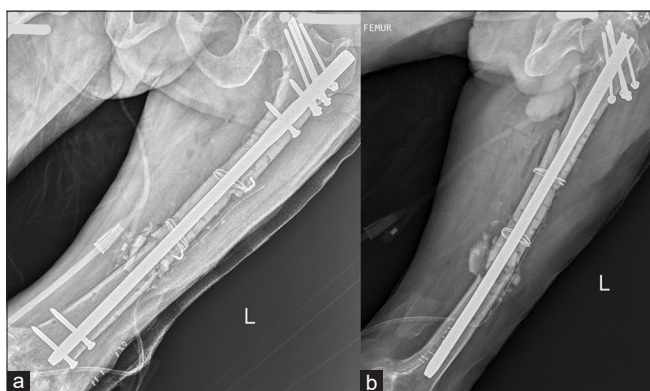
(a and b) Post-operative plain radiographs showing fixation of fracture using intramedullary interlock nail and encirclage wire
